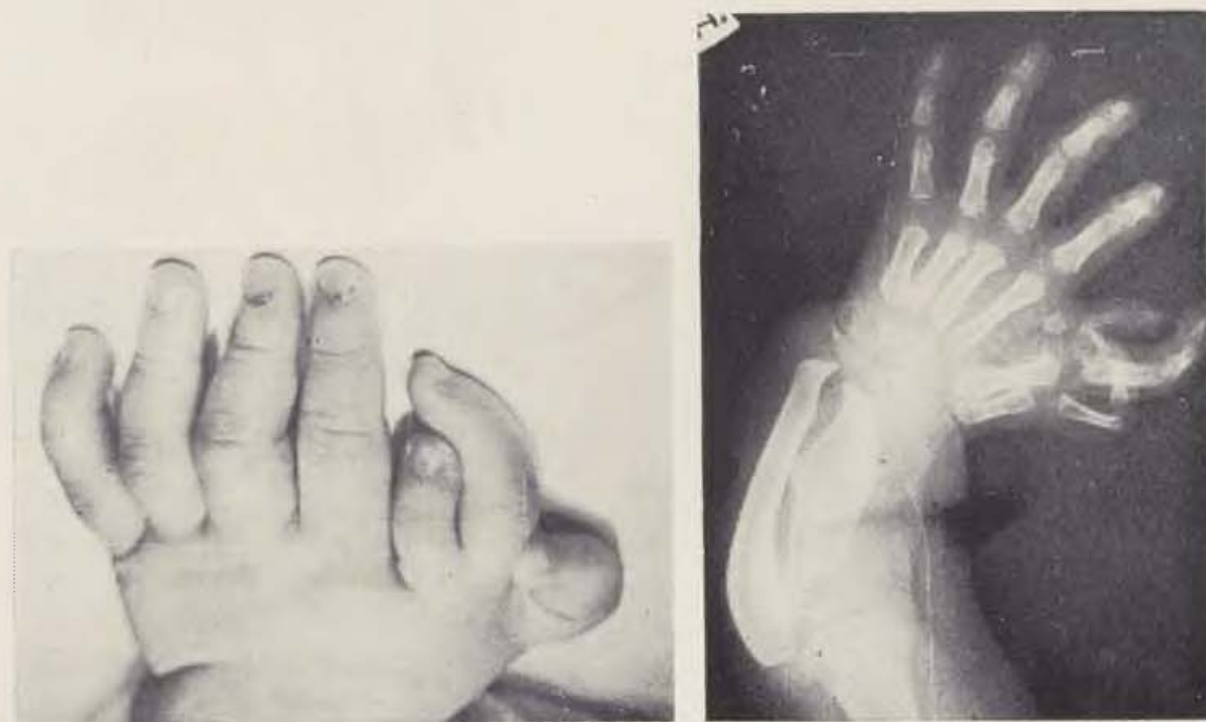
The hand before the treatment. — c) X-rays of the hand and forearm before the treatment]
